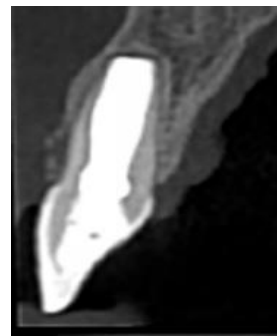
Cone-beam computed tomography of the tooth at 24 months of follow-up.
